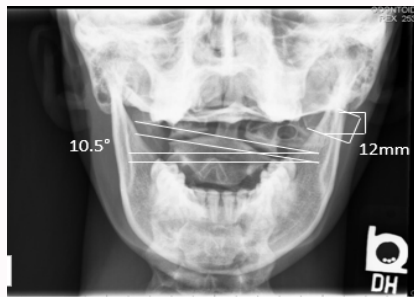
A-P Open Mouth x-ray including line analysis showing a paracondylar process off the left occipital bone measuring 12mm (+/- 2.5mm) caudal from the mastoid process. This additional articulation with the left atlas (C1) transverse process is resulting in a left lateral tilt of atlas measured at 10.5 degrees (+/- 1 degree). Base of skull, measured from mastoid to mastoid, demonstrates a neutral orientation.
